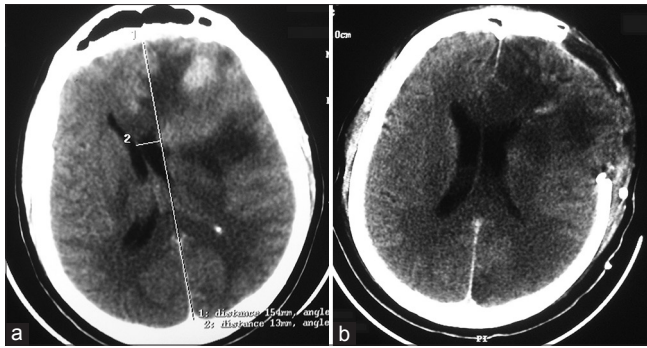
(a) Computed tomography (CT) of the skull showing cerebral mass, with marked mass effect. (b) CT showing tumor resection
